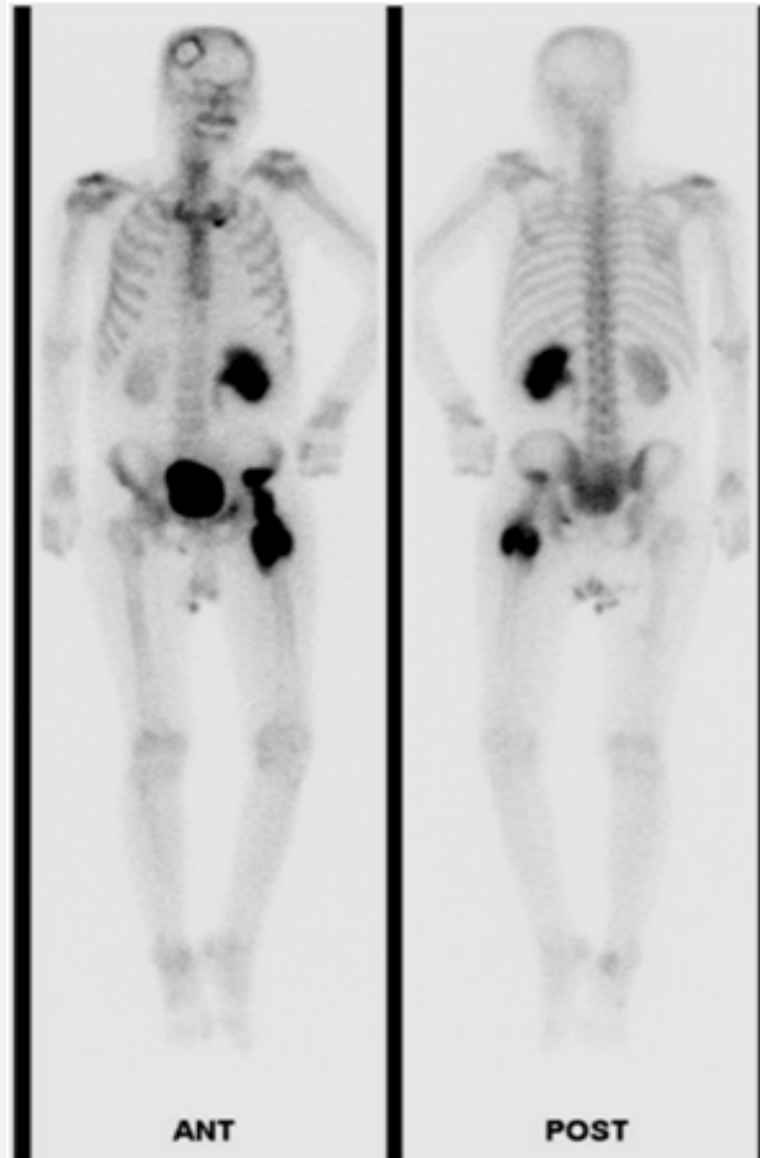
The images of whole body scintigraphy. Remarkable increased uptake of the left hip joint and proximal femur and significantly delayed tracer excretion of the left kidney, pelvis, and ureter after 4 hours on the whole body bone scan. ANT: anterior; POST: posterior.
